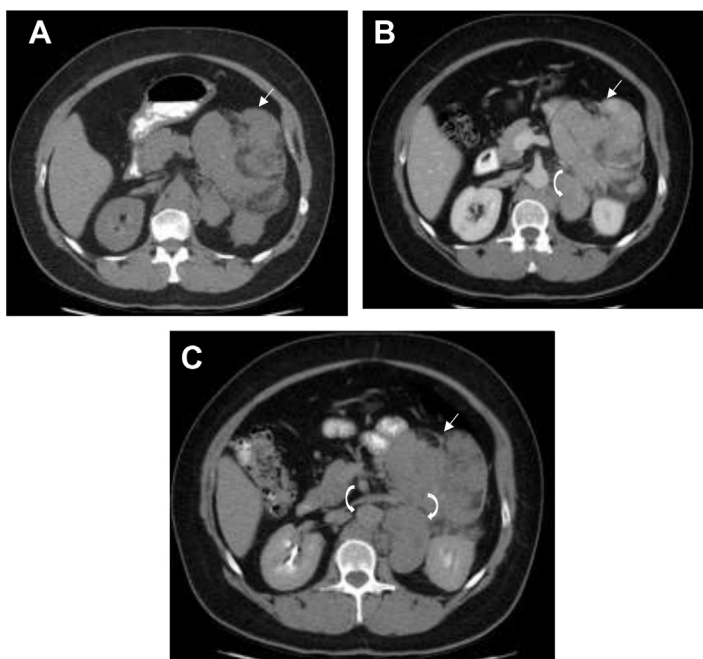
A 42-year-old patient presented with an adrenal mass discovered at an outside facility. CT was performed for diagnostic workup of hypertension, diabetes mellitus, and hirsutism with elevated androgen and cortisol levels. Axial unenhanced CT (A), contrast-enhanced CT in the portovenous phase (B) and delayed 15-minute axial CT (C) demonstrate a large heterogeneous solid mass involving the left adrenal gland, measuring 13 cm in maximal dimension (straight arrow in A, B and C) with low attenuation areas, and speckles of calcifications with associated retroperitoneal lymphadenopathy (curved arrows). This mass was surgically resected and found to represent adrenocortical carcinoma.
